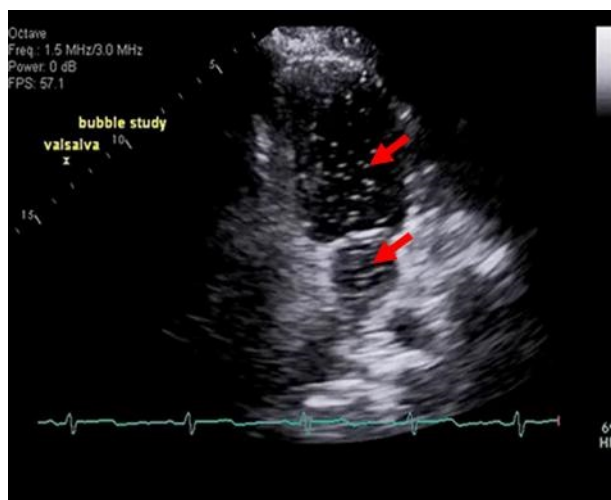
Static view from cardiac ultrasound showing bubbles on left side of the heart (arrows).
